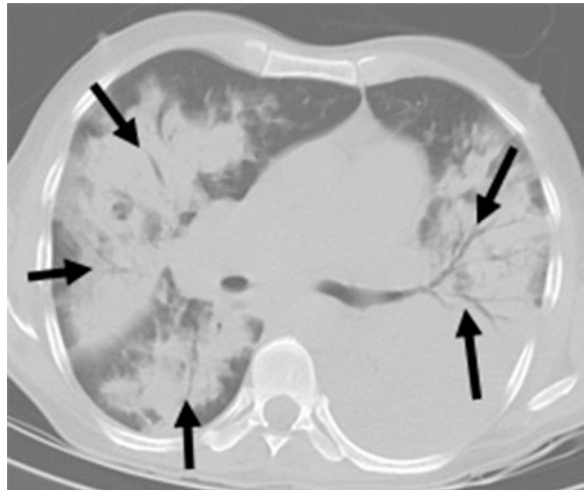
Axial chest CT. Extensive diffuse pulmonary consolidations involving the bilateral lungs. Prominent bilateral air bronchograms (black arrows)
